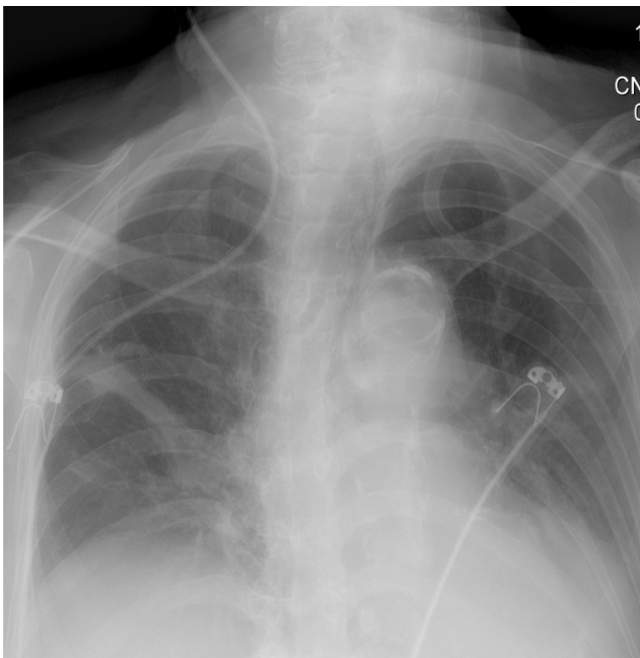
The X-ray of the chest shows the misplaced catheter – the tip entered the right subclavian vein.
